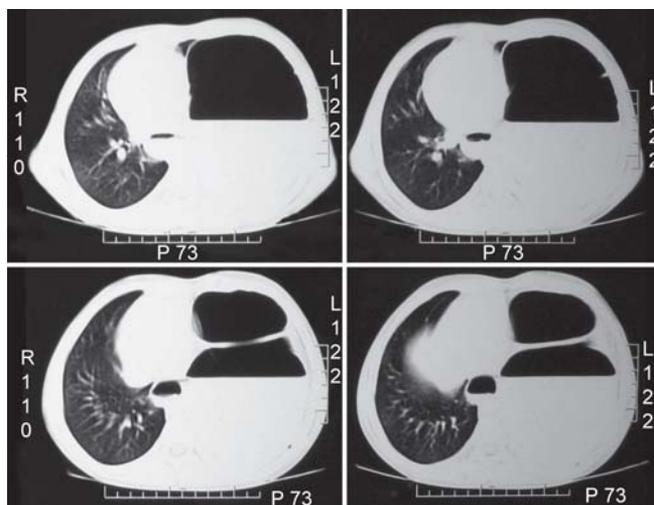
CT chest showing left diaphragmatic hernia and gastric volvulus
